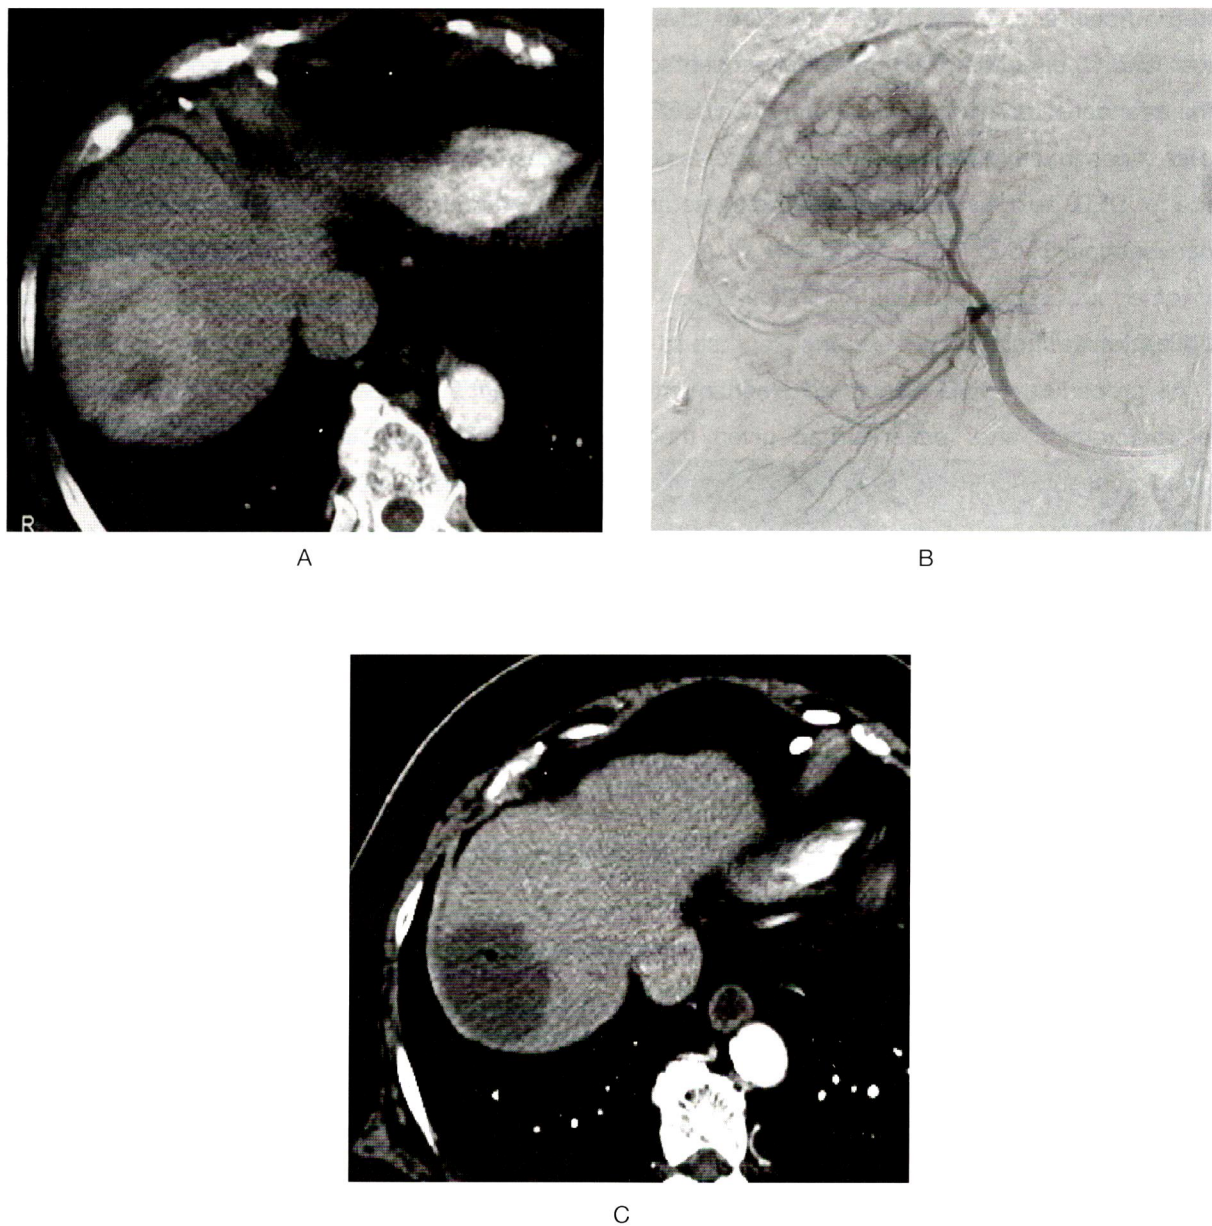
A 74-year old female with single HCC, feed by replaced RHA (A&B). Follow CT for one month showed CR after the 1st DEB-TACE (C).
